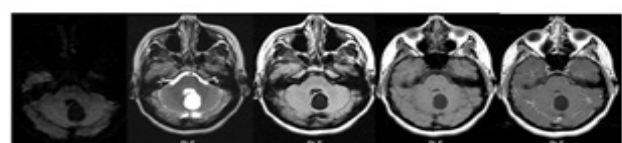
Magnetic resonance imaging performed at patient age 37 reveals a cerebellar vermian cyst. Imaging is performed in the axial plane, from right to left, and includes Diffusion Weighted Imaging, T2, T2 FLAIR, T1 weighted images and post gadolinium images. The cyst follows cerebral spinal fluid signal characteristics on all sequences and did not enhance.
